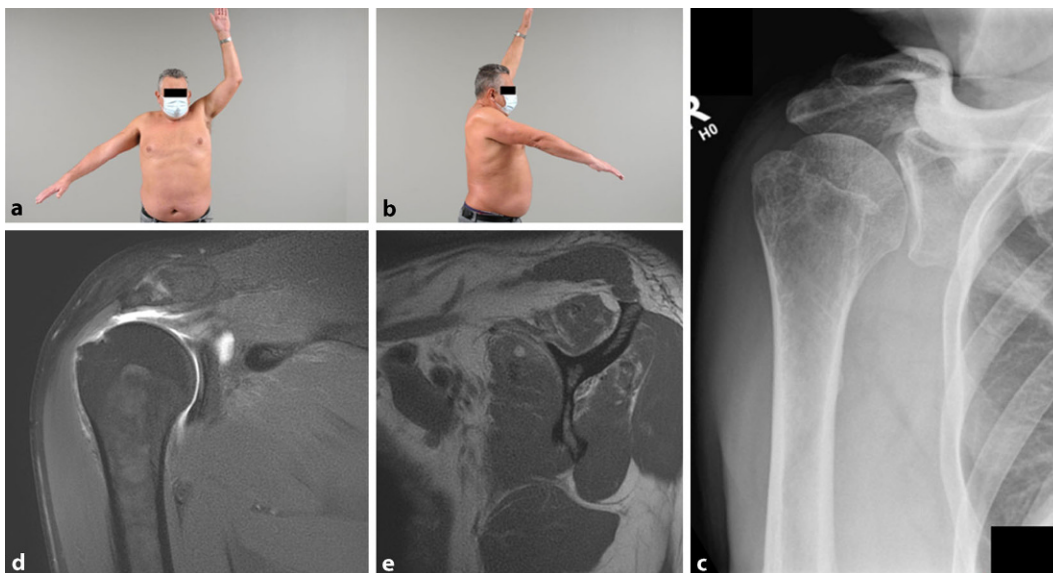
▲ Acute pseudoparesis in a 56-year-old manual worker after a fall on his right shoulder with an acute subscapularis, supra-, and infraspinatus tendon tear. Limited active range of motion with a 45° of abduction and b 60° of anterior flexion. c Anteroposterior radiographs show slight cranialization of the humeral head with an acromiohumeral distance of 7 mm. d Axial MRI shows full-thickness supraspinatus tendon tear with e fatty infiltration grade 2 of the supra- and infraspinatus muscle. This patient was treated with arthroscopic rotator cuff repair
